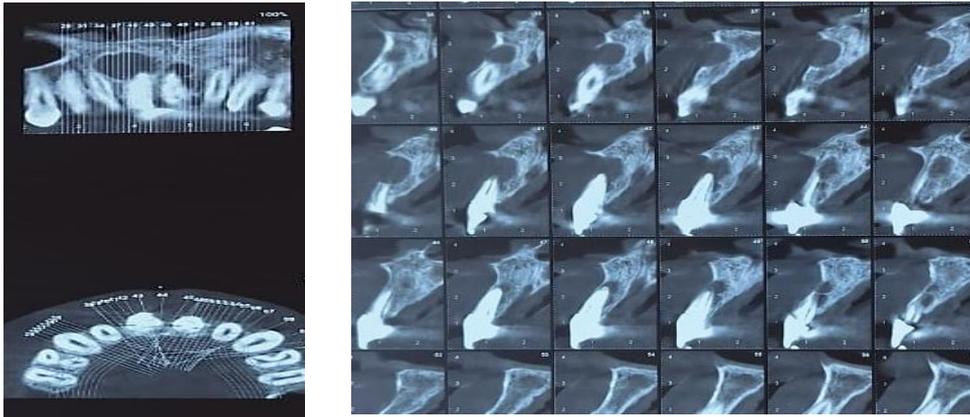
CBCT images showing two well-defined periapical radiolucent lesions associated with teeth 11 and 21
